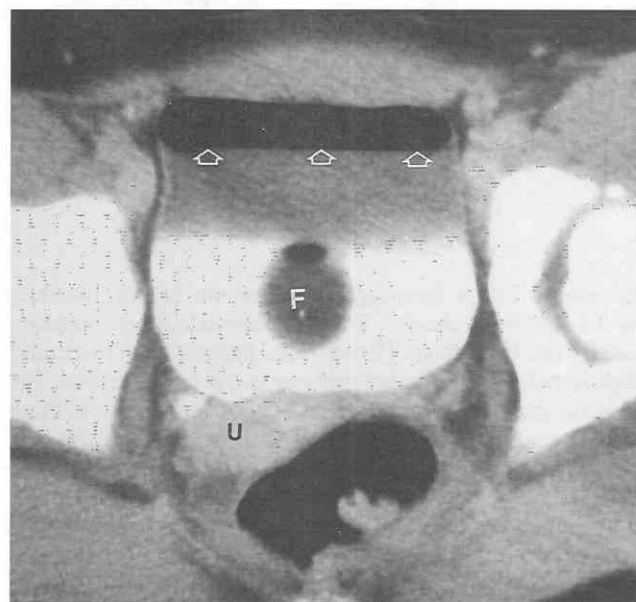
Normal prepubertal female pelvis. CT scan of a 7-year-old girl. The uterus (U) appears as a homogeneous, oval soft tissue structure posterior to the bladder. The endometrial cavity is indistinguishable from the myometrium. Neither ovary is visualized. The normal bladder wall is thin. On this contrast-enhanced scan, the opacified urine occupies the dependent portion of the bladder and unopacified urine layers are above it. A Foley catheter (F) is present, accounting for the air-fluid level (open arrows).
